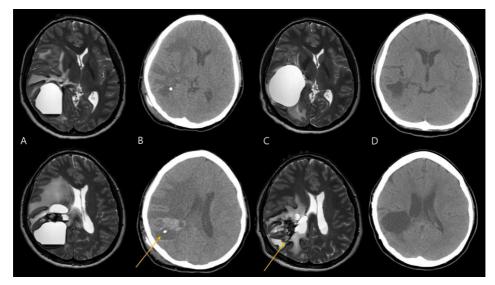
Case (case 13) that shows RIOH accompanied with cyst. A) Multiple cysts and RIOH were observed 7.4 years after the total obliteration of the AVM nidus. The patient presented with seizure. She underwent Ommaya reservoir insertion for large cyst that was located posterior to the RIOH. B) On computed tomography (CT), the cyst became smaller 1 day postoperatively. Her symptoms also improved. C) Seizure recurred 1 year postoperatively. There are newly developed large cyst and growing RIOH. Surgical resection of the RIOH and cysts was performed. D) CT images showed absence of cysts and RIOH. There were
